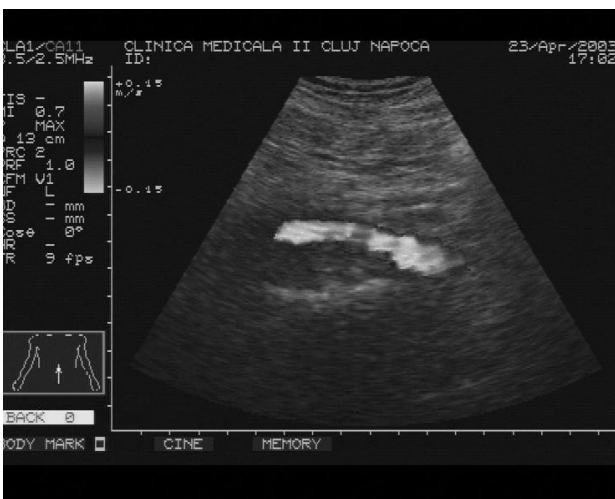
Postoperative echo-Doppler aspect of the reconstructed aortic segment.
